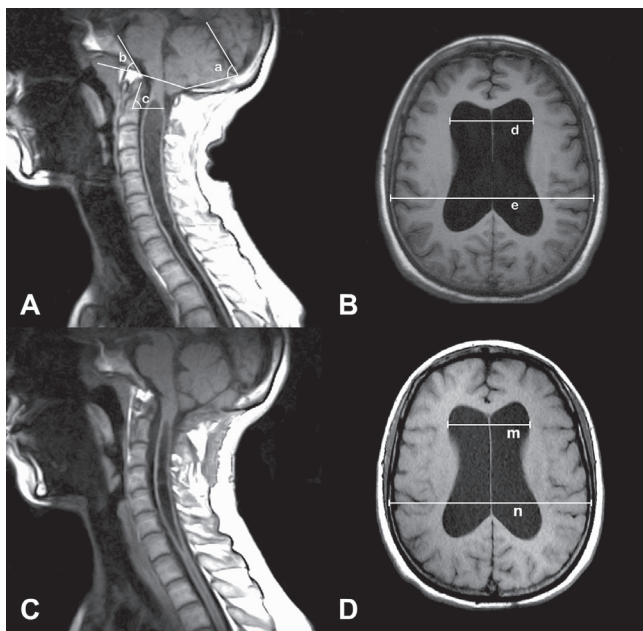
A: Preoperative cervical T₁-weighted sagittal magnetic resonance (MR) image revealing tonsillar herniation with a holocord syrinx, and showing the measurement of the tentorial angle (a), the clival angle (b), and the angulation of the odontoid process (c). B: Preoperative brain T₁-weighted axial MR image showing ventricular dilation and the measurement of Evans' index (d/e). C: Postoperative cervical T₁-weighted sagittal MR image showing reduction in syrinx size. D: Postoperative brain T₁-weighted axial MR image showing the measurement of postoperative Evans' index (m/n) and demonstrating no obvious change of ventricular size after surgery. (A–D were taken from the same patient, case number 28; C and D were taken 6 months after surgery).
